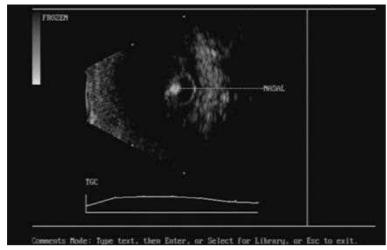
B-Scan Ultrasound Showing a Scolex in a Case of Intraocular Cysticercosis.
